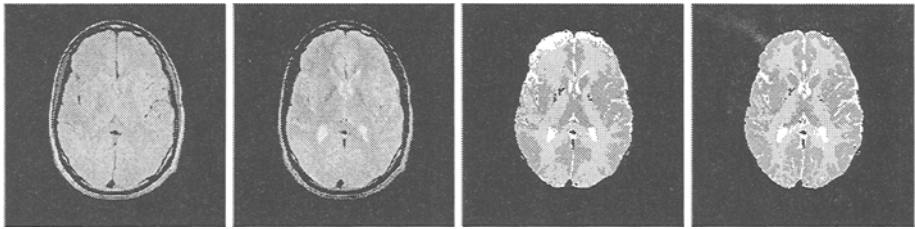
Segmentation of multi-channel data. From left to right: PD and T2-weighted images, segmentation with the EM algorithm without bias correction and with the extended EM algorithm.
